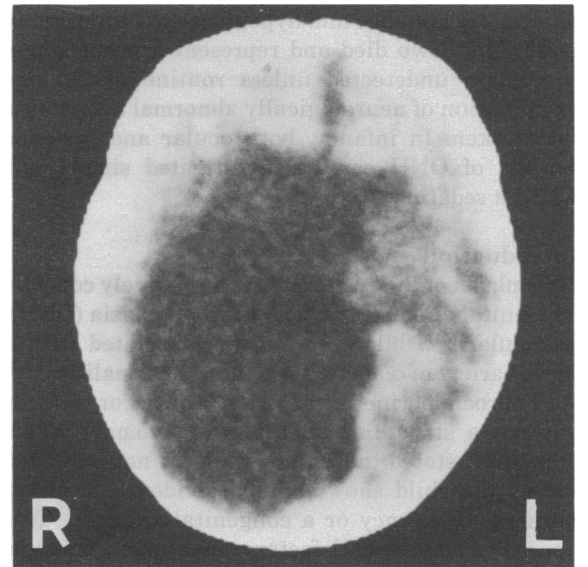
CT scan from Case 4 showing the large fluid-filled cavity and surrounding cerebral tissue, more evident on the left side
